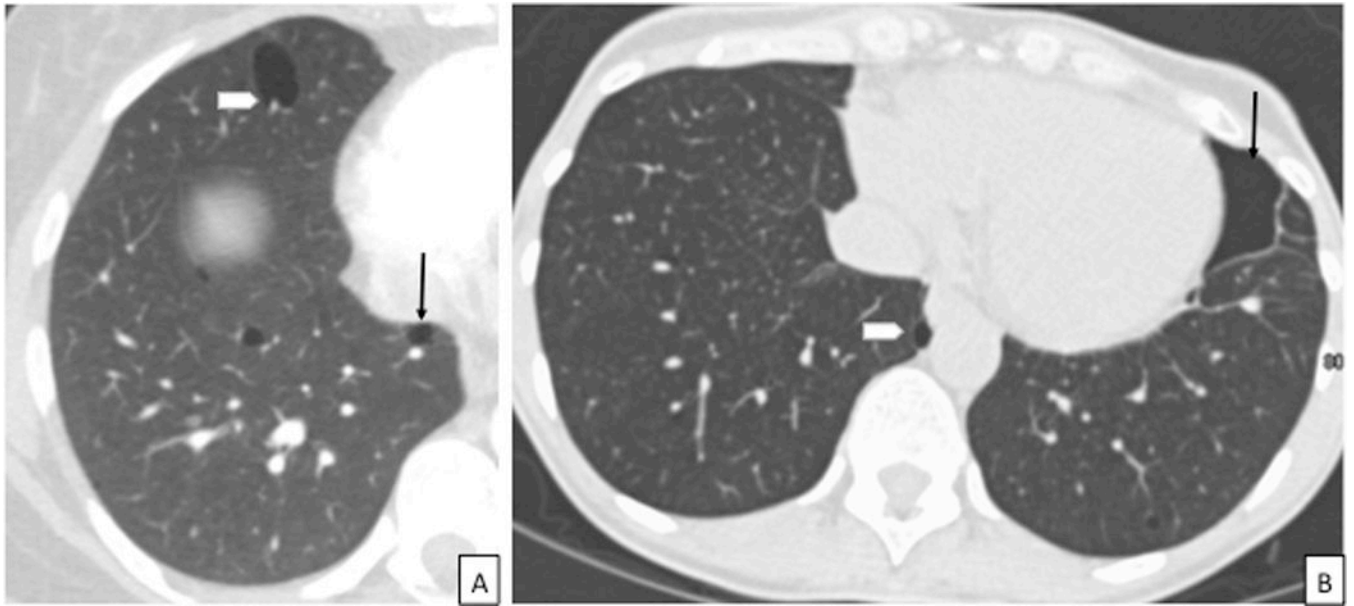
CT images in a patient with BHD. 3A: Axial CT chest showing the characteristic thin-walled, lentiform cysts abutting the pleura (arrow) and pulmonary vasculature (arrowhead), in a lower lobe distribution. 3B: CT chest showing a chronic loculated left sided pneumothorax in a patient with BHD (arrow). Notice the presence of characteristic lentiform-shaped BHD cyst abutting the mediastinal pleura (arrowhead) in addition to the loculated pneumothorax. CT = Computed Tomography, BHD = Birt-Hogg-Dubé syndrome.
